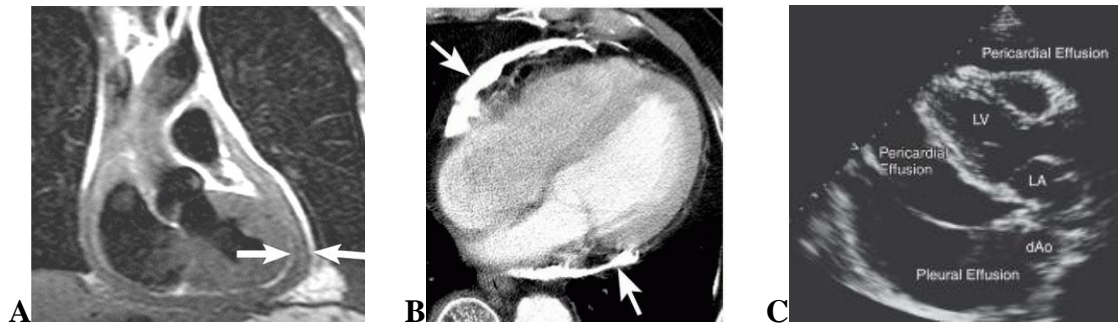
Constrictive pericarditis. (A) Coronal T1-weighted MR image shows abnormally thickened pericardium (arrows) outlined by epicardial and mediastinal fat. (B) Contrast CT shows dense pericardial calcification (arrows) in a patient with a history of hemopericardium. (C) Two-dimensional echocardiographic view in a patient with both a pleural and pericardial effusion. The echo-free space anterior and immediately posterior to the heart is pericardial fluid. The parietal pericardial layer divides the posterior pericardial fluid from the pleural fluid. The location of the descending thoracic aorta in relation to the fluid is often helpful in distinguishing pleural from pericardial fluid. The descending aorta is seen in cross section behind the heart. Pericardial fluid lies between the heart and the aorta while pleural fluid is seen posterior to both the heart and the aorta. Ao, aorta; dAo, descending aorta; LA, left atrium; LV, left ventricle
